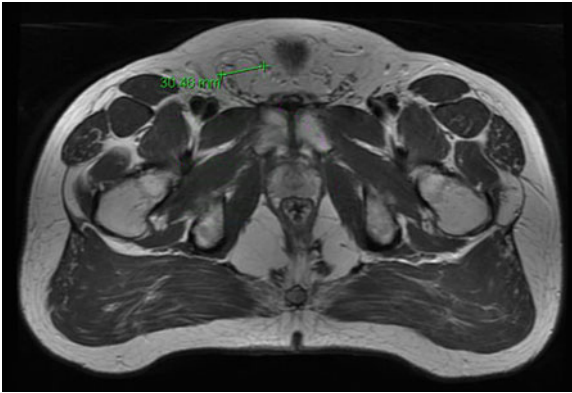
Right inguinal hernia on MRI.
